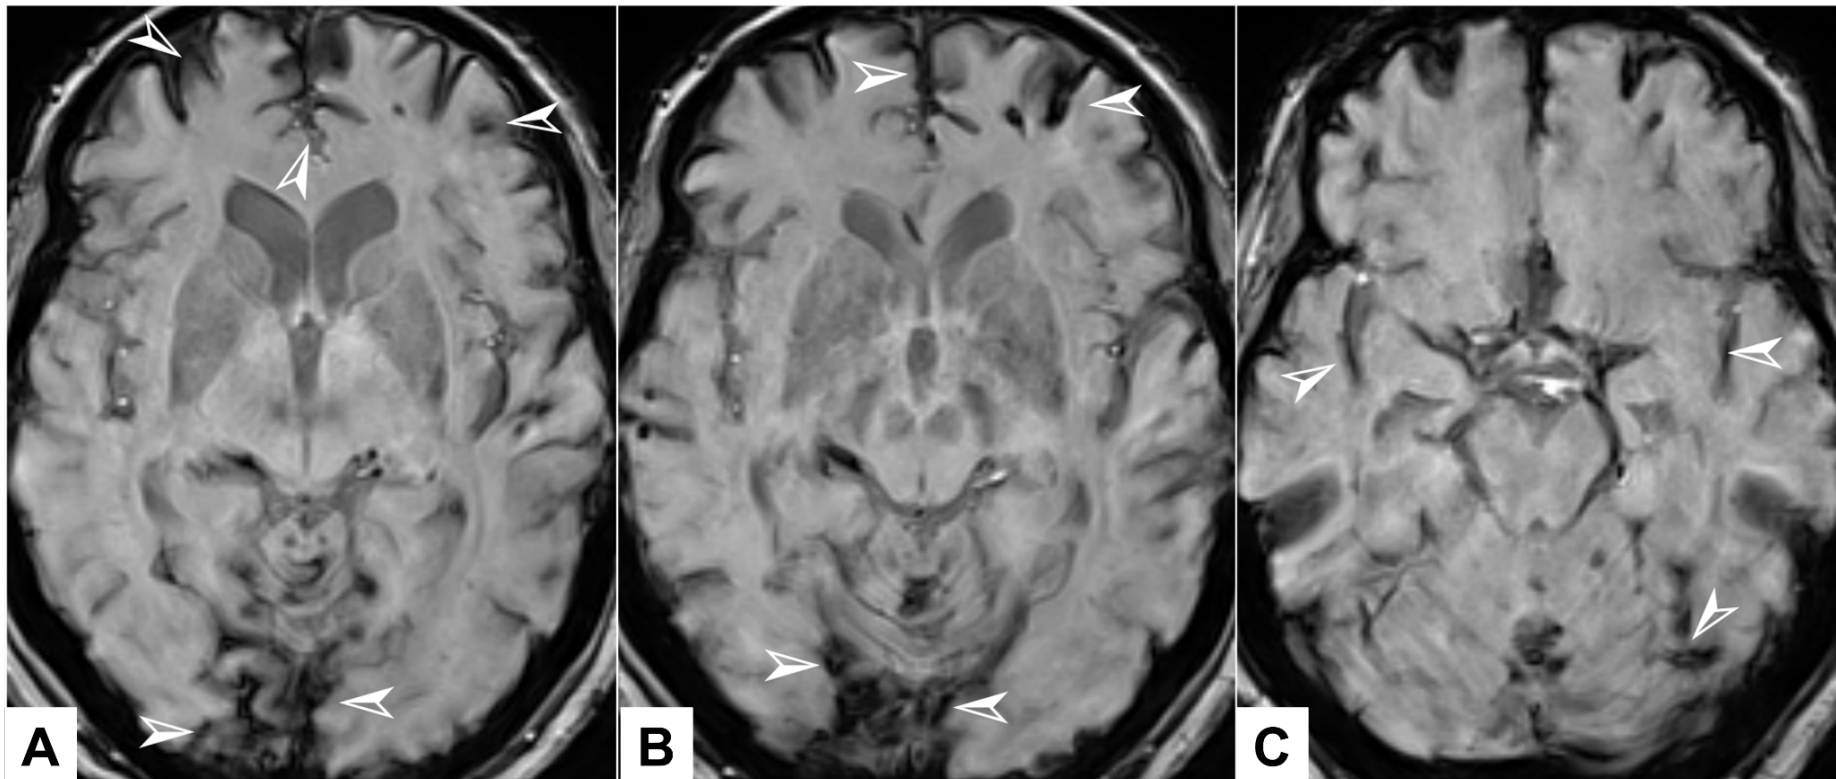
Axial susceptibility weighted magnetic resonance images of the supratentorial involvement in Case 4. Appearances of signal dropout suggestive of haemosiderin deposits are marked with arrowheads. A-C: cephalad to caudal images provided. Images: © UK Biobank.
